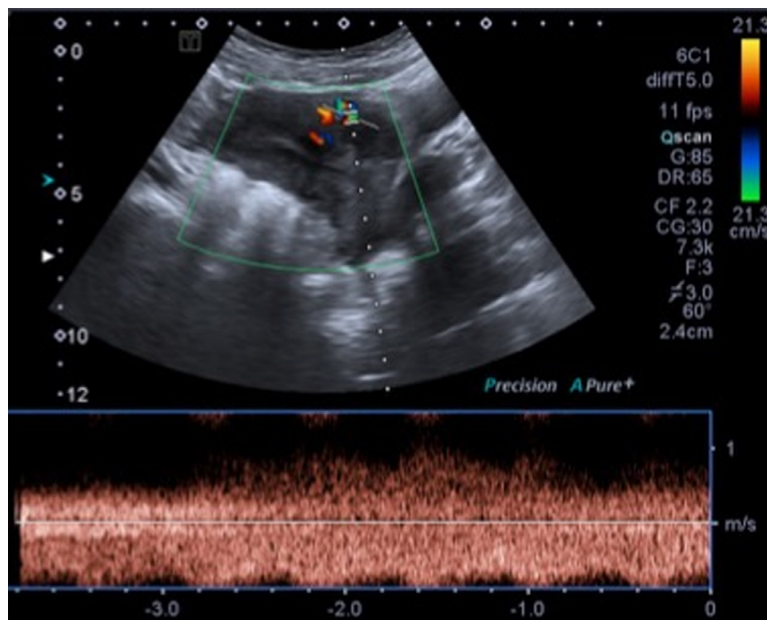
A 28-years-old female with menometrorrhagia a history of 1 previous cesarean section and intracavitary ablation for myoma. Transabdominal Color-Doppler US showing a focal vascular lesion into the uterine wall with mixed arterio-venous Doppler pattern.
